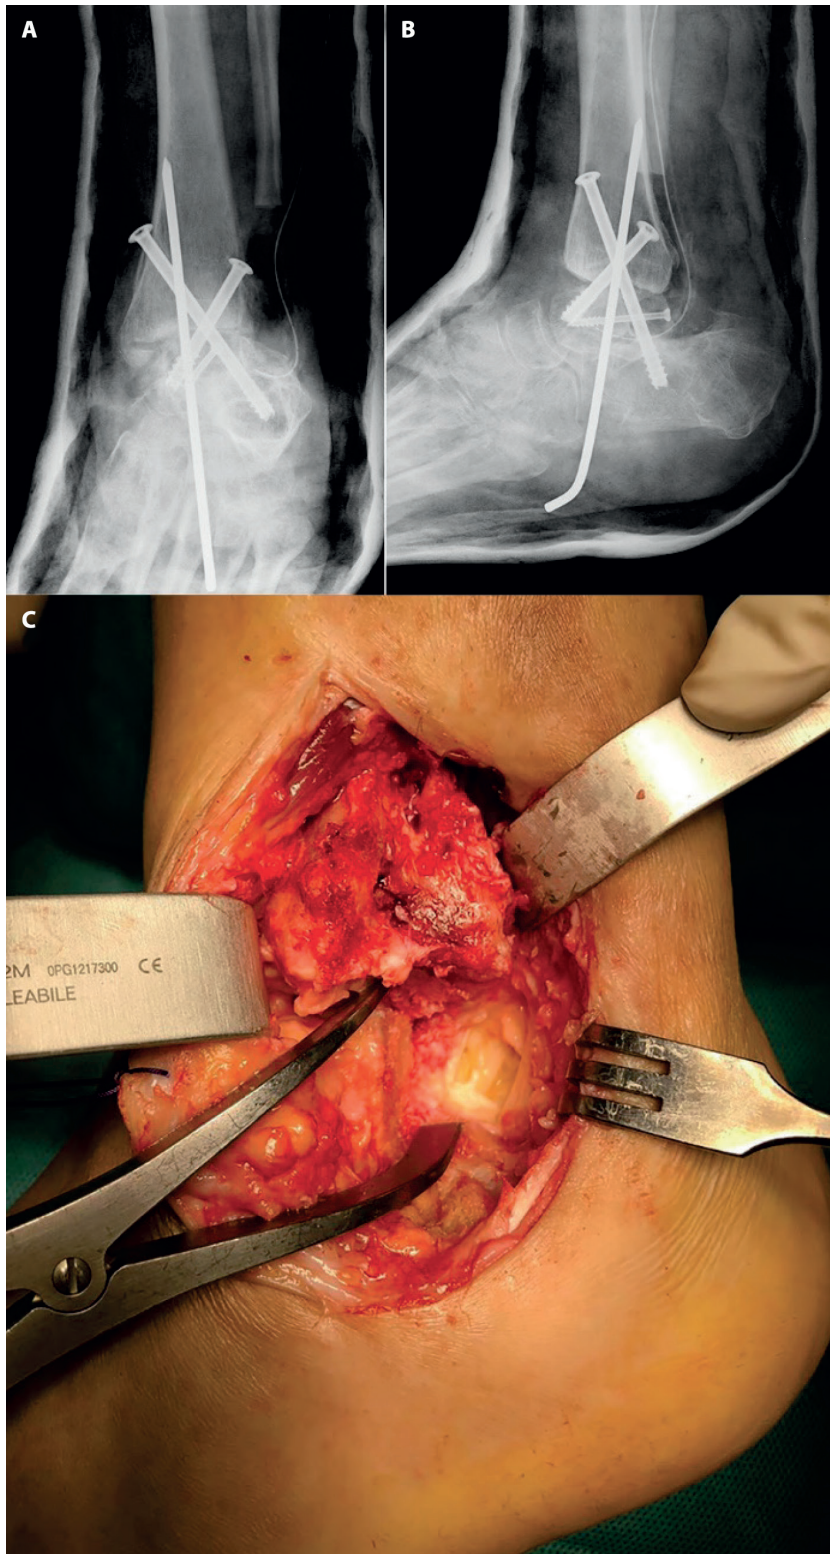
Joint's stabilization and external fixator positioning. (A) Postoperative anteroposterior and (B) lateral radiographs.
